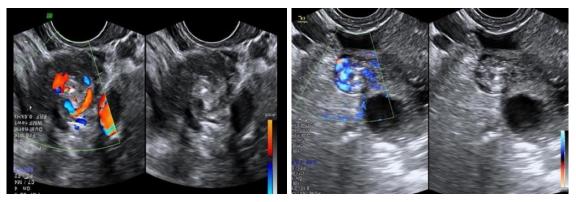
Ultrasound images of ovarian torsion with the "whirlpool sign" (20).
